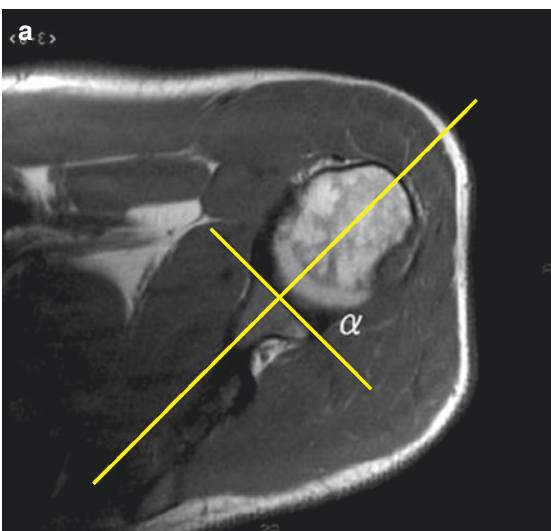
Glenoid version estimation: MRI
